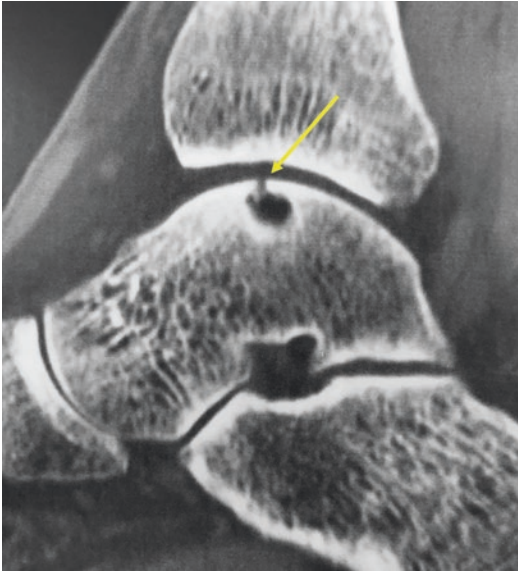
CT image of talus osteochondral defect with bone cyst formation (*yellow arrow*). A cartilage defect in a congruent joint enables joint fluid to penetrate the subchondral bone leading to osteolysis. Bony defects are better evaluated in CT opposing to MRI
